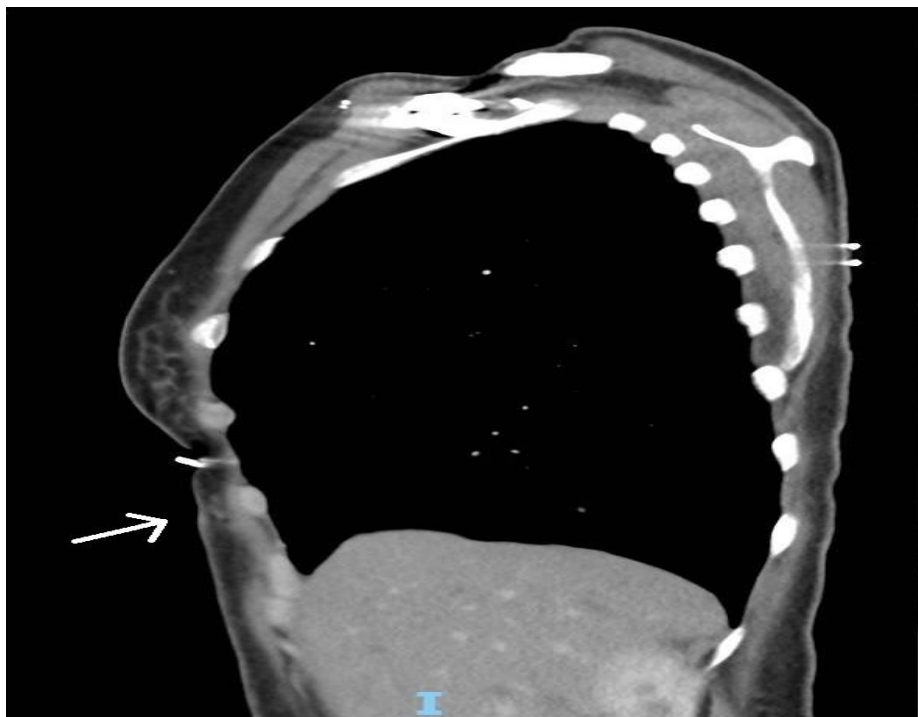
CT scan (sagittal) showing supernumerary breast tissue within subcutaneous tissue (arrow) inferior to orthotopic breast.
